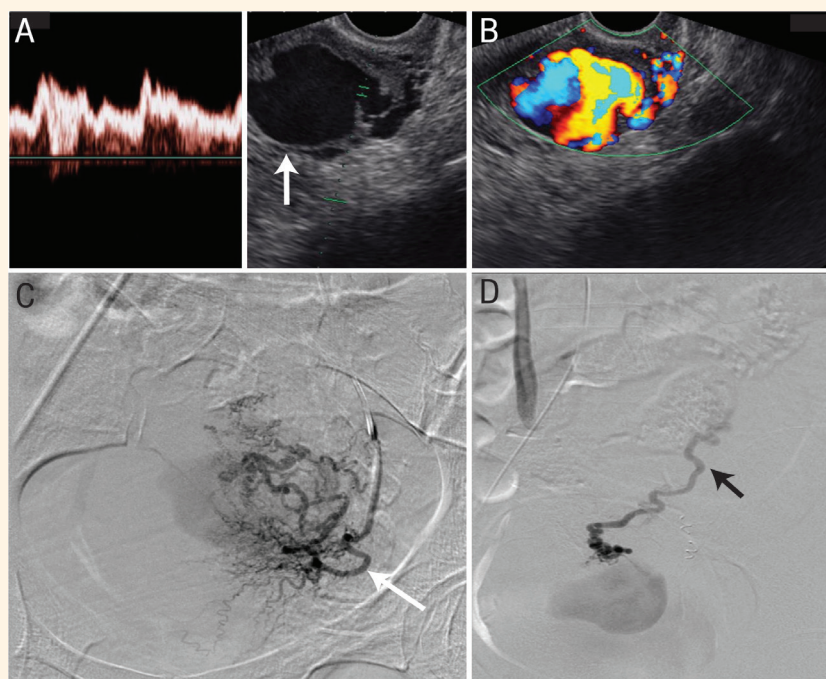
Moderate vaginal bleeding in a 25-year-old demonstrated via a (A) Doppler ultrasound showing a mosaic colour pattern in the myometrium on the right side extending into endometrium, indicating both arterial and venous flow (arrow), (B) digital subtraction angiography (DSA) image showing the arteriovenous malformation (AVM) supplied by right uterine artery, (C) DSA image showing the early draining vein (arrow) and (D) Post-embolisation DSA image showing resolution of the AVM.
